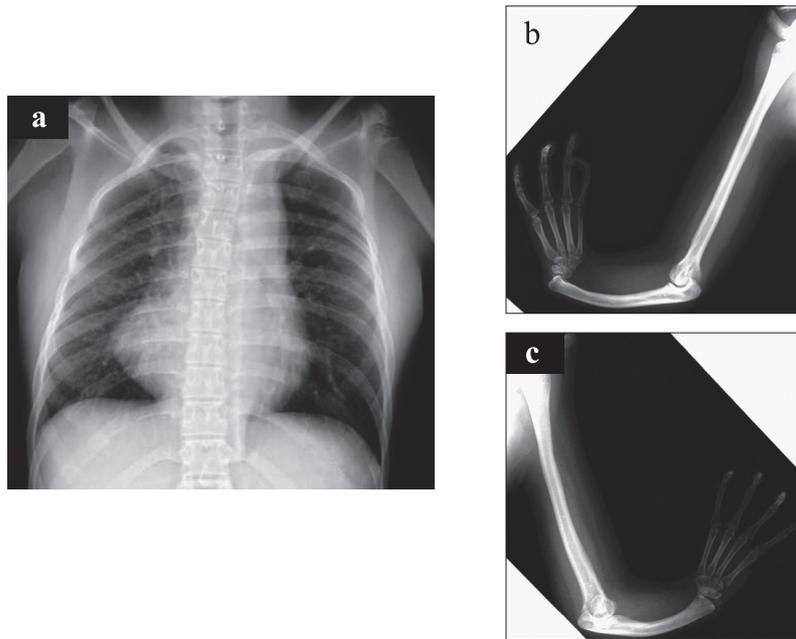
Chest X-ray examination revealed dextrocardia (a), and an X-ray of her arms showed bilateral agenesis of the radial bone and first finger {right arm (b),left arm (c)}.
